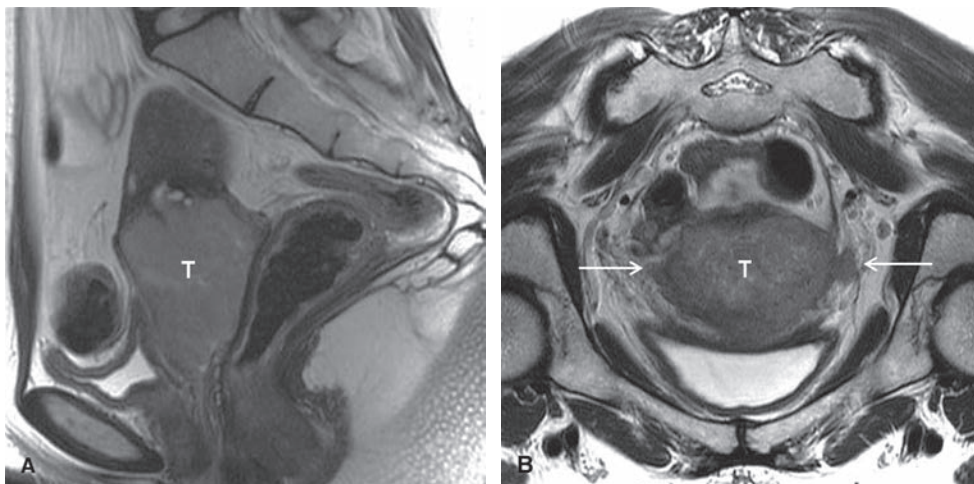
Stage IIB cervical carcinoma. Sagittal (A) and axial oblique (B) T2W FSE MR images show a large cervical cancer (T in A, B). On the axial oblique image there is a spiculated tumor to parametrium interface on the right and a tumor nodule present in the left parametrium in keeping with bilateral parametrial invasion (arrows in B).
